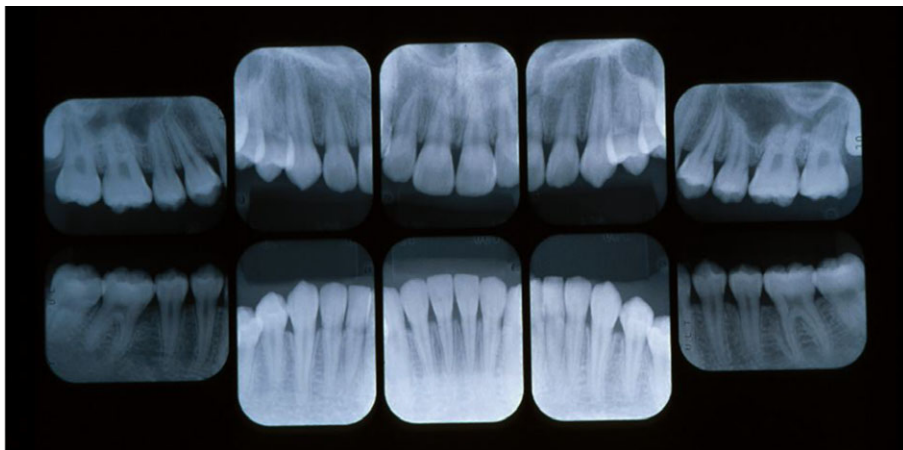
Full-mouth radiographs taken November 9, 1995.
